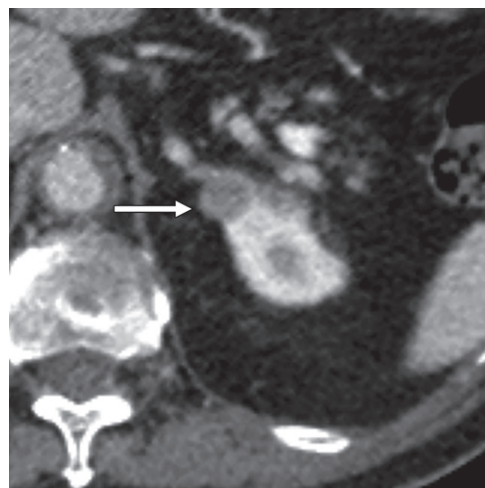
Renal mimics of adrenal pathologic conditions. Axial postcontrast CT image shows a lesion (arrow) contiguous with the left adrenal gland and upper pole of the left kidney. A left renal cyst (attenuation, 11 HU) was diagnosed owing to the presence of the claw sign, which favors a renal origin.
